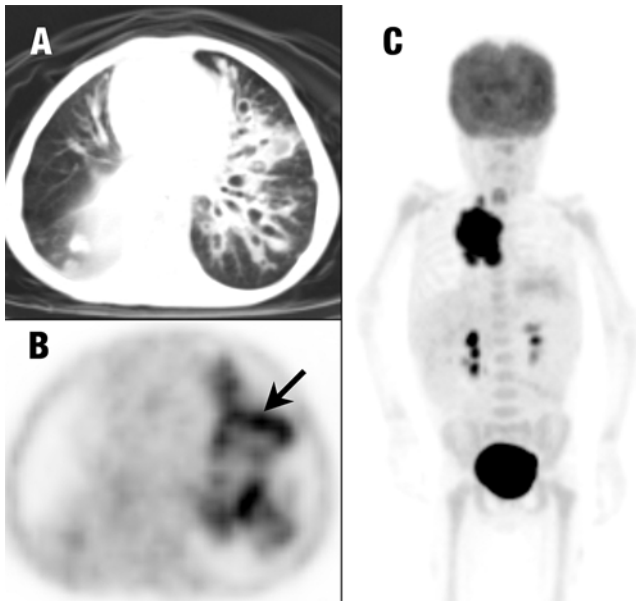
PET/CT demonstrated widespread bronchiectasis, accompanying infiltrations and peribronchovascular thickening in the left lung (A, B) and ^{18}F -FDG-avid supradiaphragmatic lymph nodes (C) (arrows).
